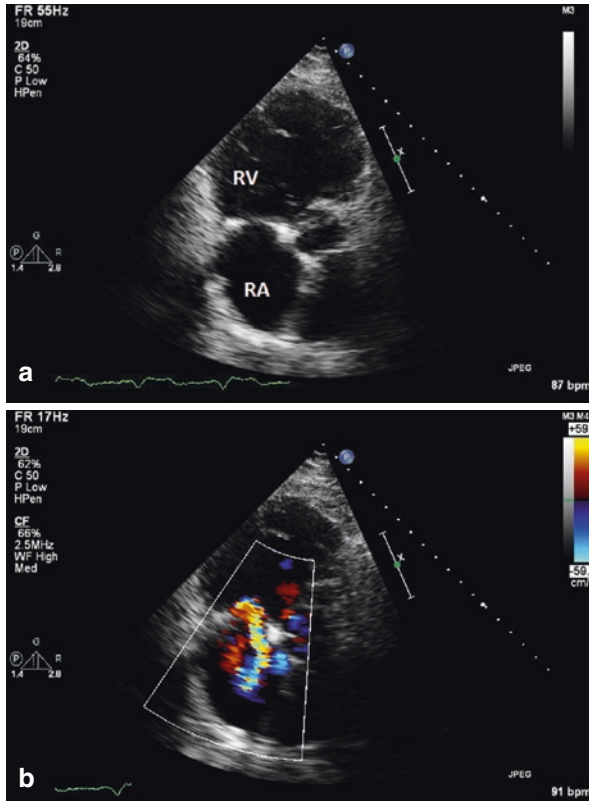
(a) View of Carpentier Edwards ring in the tricuspid position. (b) Doppler echocardiography shows moderate residual tricuspid regurgitation
